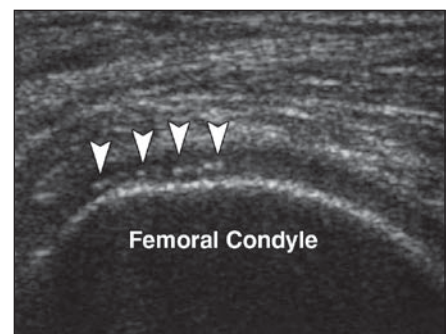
39-year-old man who had been bothered by knee pain for more than 1 year, especially while riding his bicycle competitively. Knee radiography and MRI were normal. Longitudinal sonogram at level of lateral femoral condyle reveals unsuspected calcification of hyaline cartilage (arrowheads). This area was focally tender to probe pressure, confirming chondrocalcinosis as underlying cause of pain.
